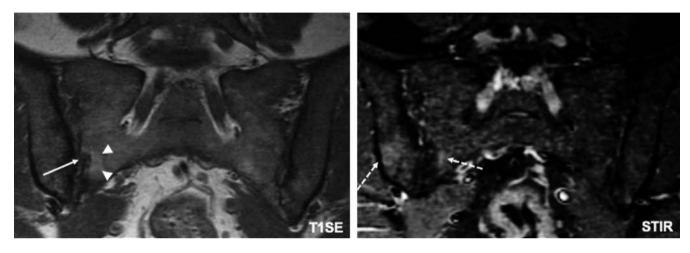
Active erosive sacroiliitis: 36-year old (human leukocyte antigen-B27 not available) female with Crohn's disease (CD) for 12 y, moderate CD activity, remote history of peripheral arthritis (absent at the time of magnetic resonance imaging) and inflammatory back pain. The T1SE sequence (left panel) shows a sacral erosion (arrow) with perifocal fat metaplasia (arrowheads) in the right distal sacroiliac joint. The structural lesions are surrounded by bone marrow edema (broken arrows) of both sacrum and ilium (short tau inversion recovery scan, right panel)
